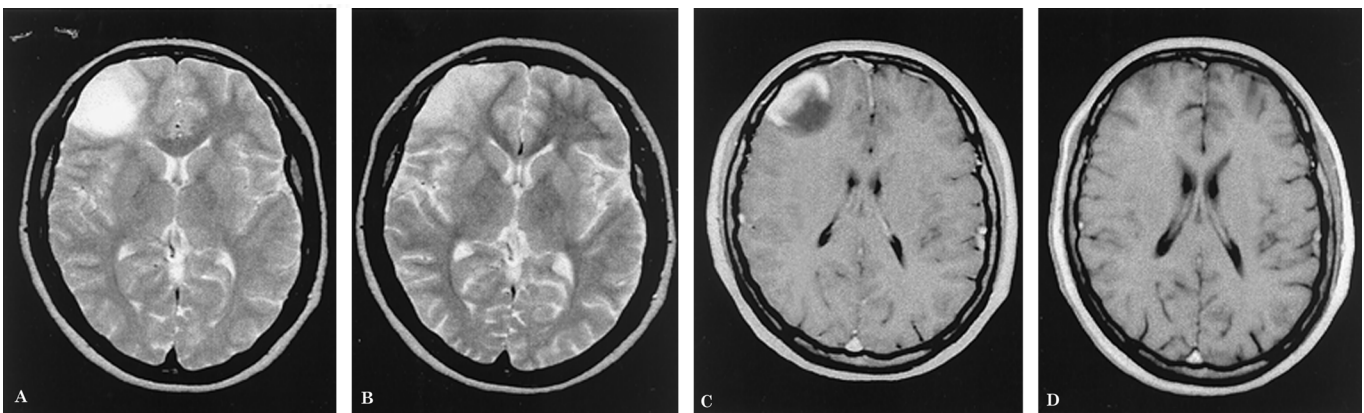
weighted (A and B) and enhanced T1-weighted (C and D) axial MRI. MRI from July 1996, performed a few days after a generalized seizure, shows a gadolinium-enhancing right frontal lesion (A and C). MRI from September 1996 shows a marked regression of the lesion with complete disappearance of the cortical area of contrast enhancement (B and D).
